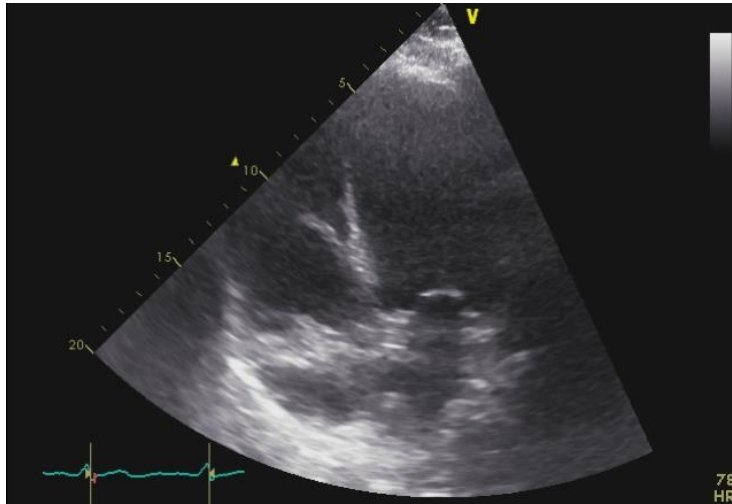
Apical 4 chamber some years before cancer diagnosis and mastectomy. The overall image quality is overall comparable with the image obtained after mastectomy
